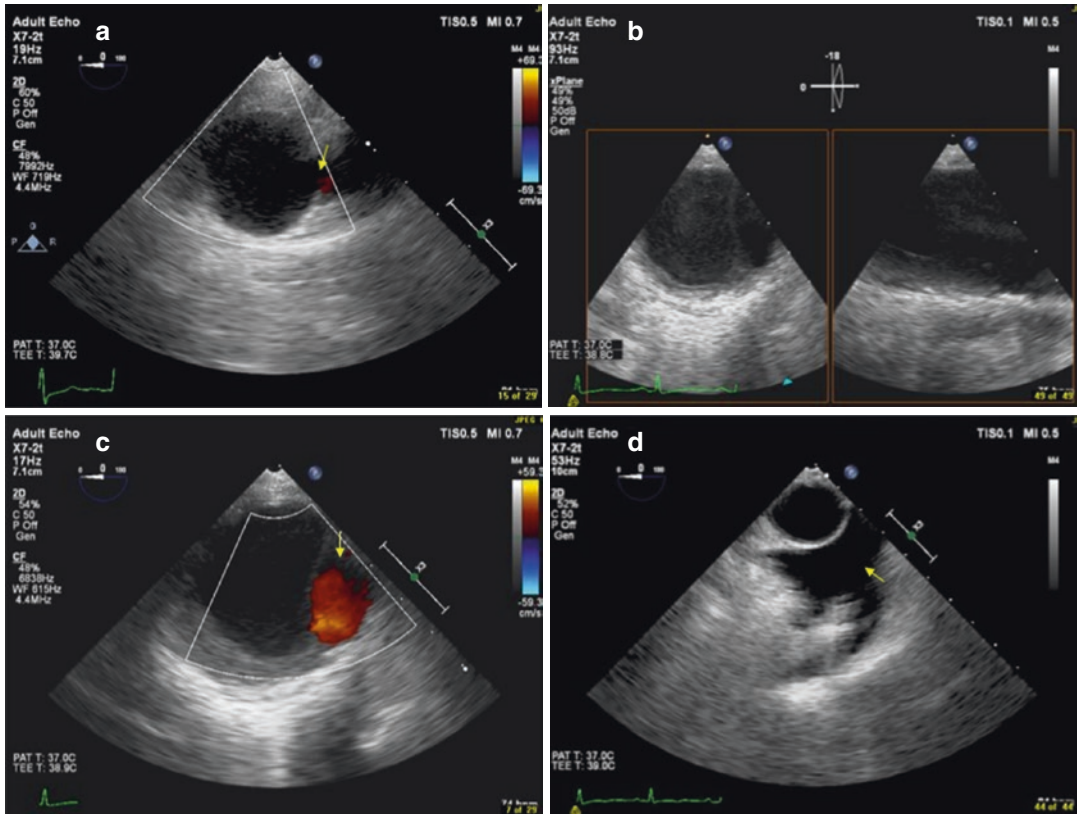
Transesophageal echocardiography for evaluation of the thoracic aorta. (a) Color flow Doppler demonstrating flow to the left subclavian artery from the aortic arch. (b) 2D Biplane used to evaluate orthogonal aspects
